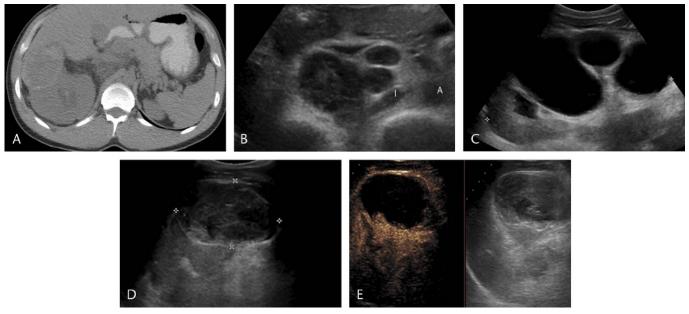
A, Nonenhanced CT performed on a 35-year-old man with impaired renal function shows a complex cyst arising from the right kidney, with a thickened wall. The right kidney itself is enlarged. B, An axial gray-scale image of the midline abdomen shows multiple enlarged retroperitoneal lymph nodes, the largest of which appears cystic compared with the smaller, more solid-appearing lymph nodes. C and D, An axial image of the right kidney confirms a large solid and cystic kidney with a dominant indeterminate anterior exophytic mass. E, Contrast-enhanced image of the exophytic mass shown in D shows an enhancing nodule projecting into an otherwise simple cystic mass, concerning for renal neoplasm.
